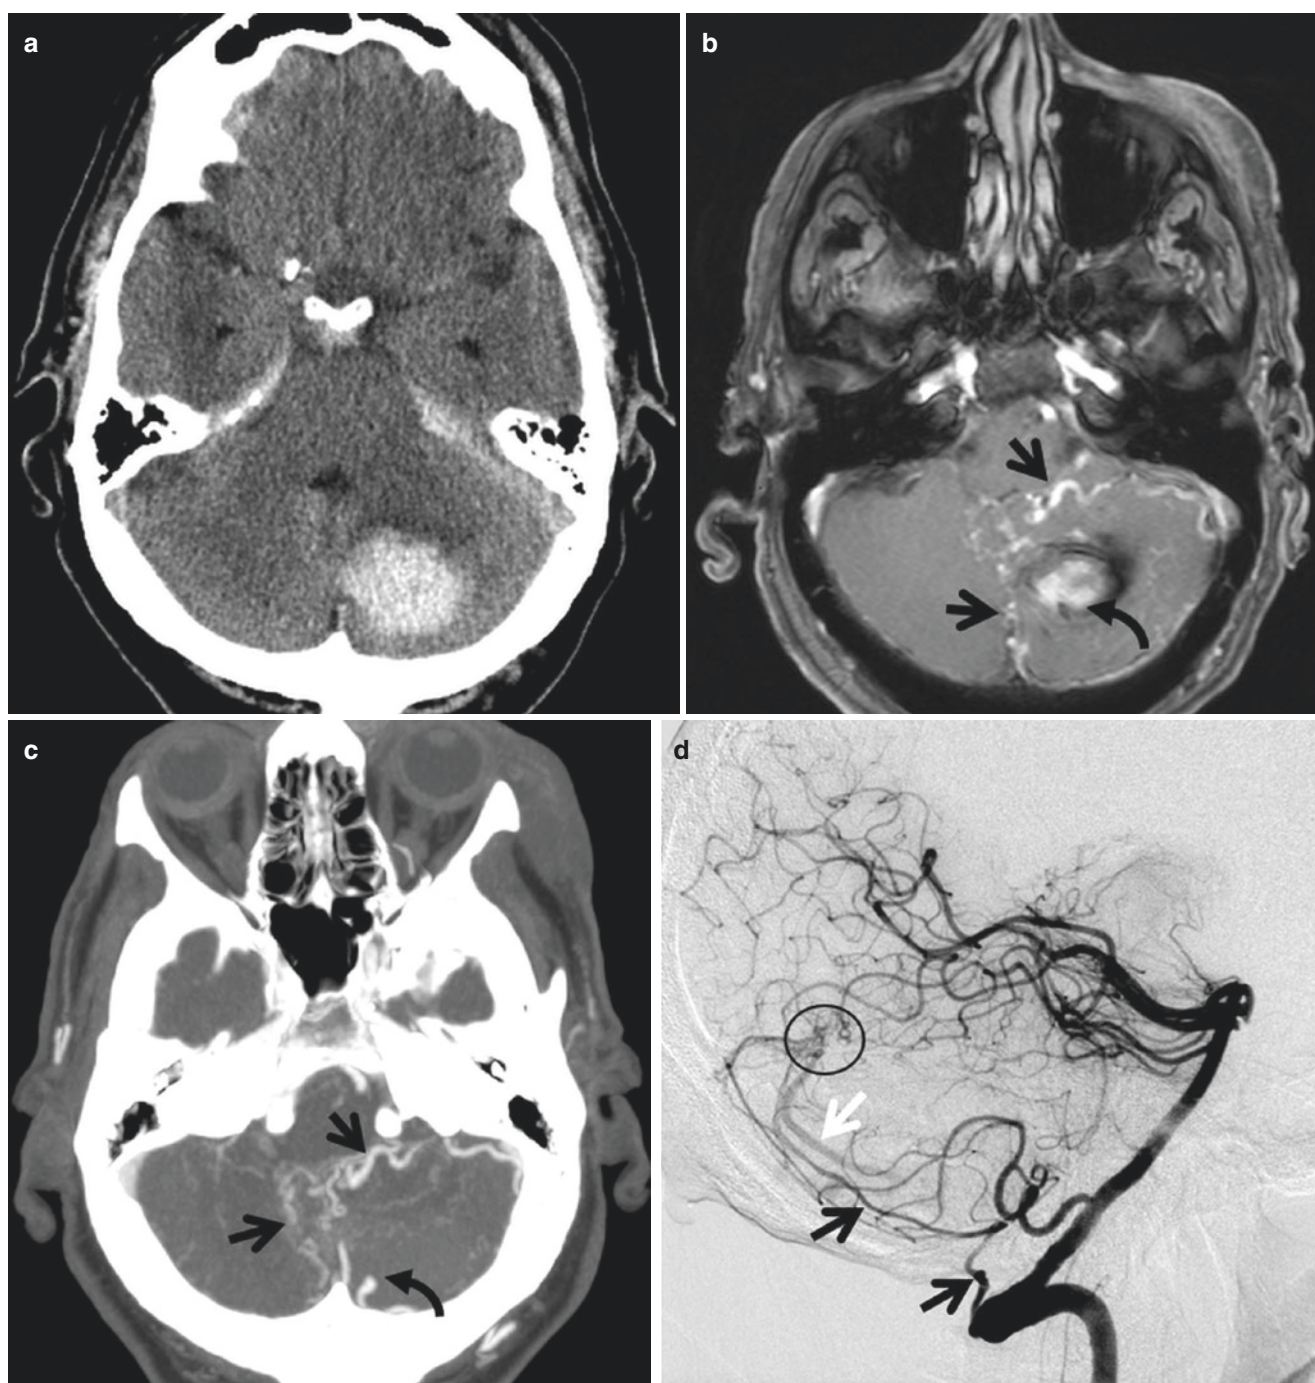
Cerebellar DAVF. (a) NCCT shows acute left cerebellar hemorrhage. (b) Postcontrast axial T1 MRI demonstrates multiple enhancing vessels (arrows) in the left cerebellum surrounding the hematoma (curved arrow), suspicious for an underlying high-flow vascular malformation. (c) Axial CTA again demonstrates multiple abnormal vasculature in the left cerebellum (arrows). A discrete nidus is not seen but a small aneurysm is identified (curved arrow). (d) Lateral view of catheter
